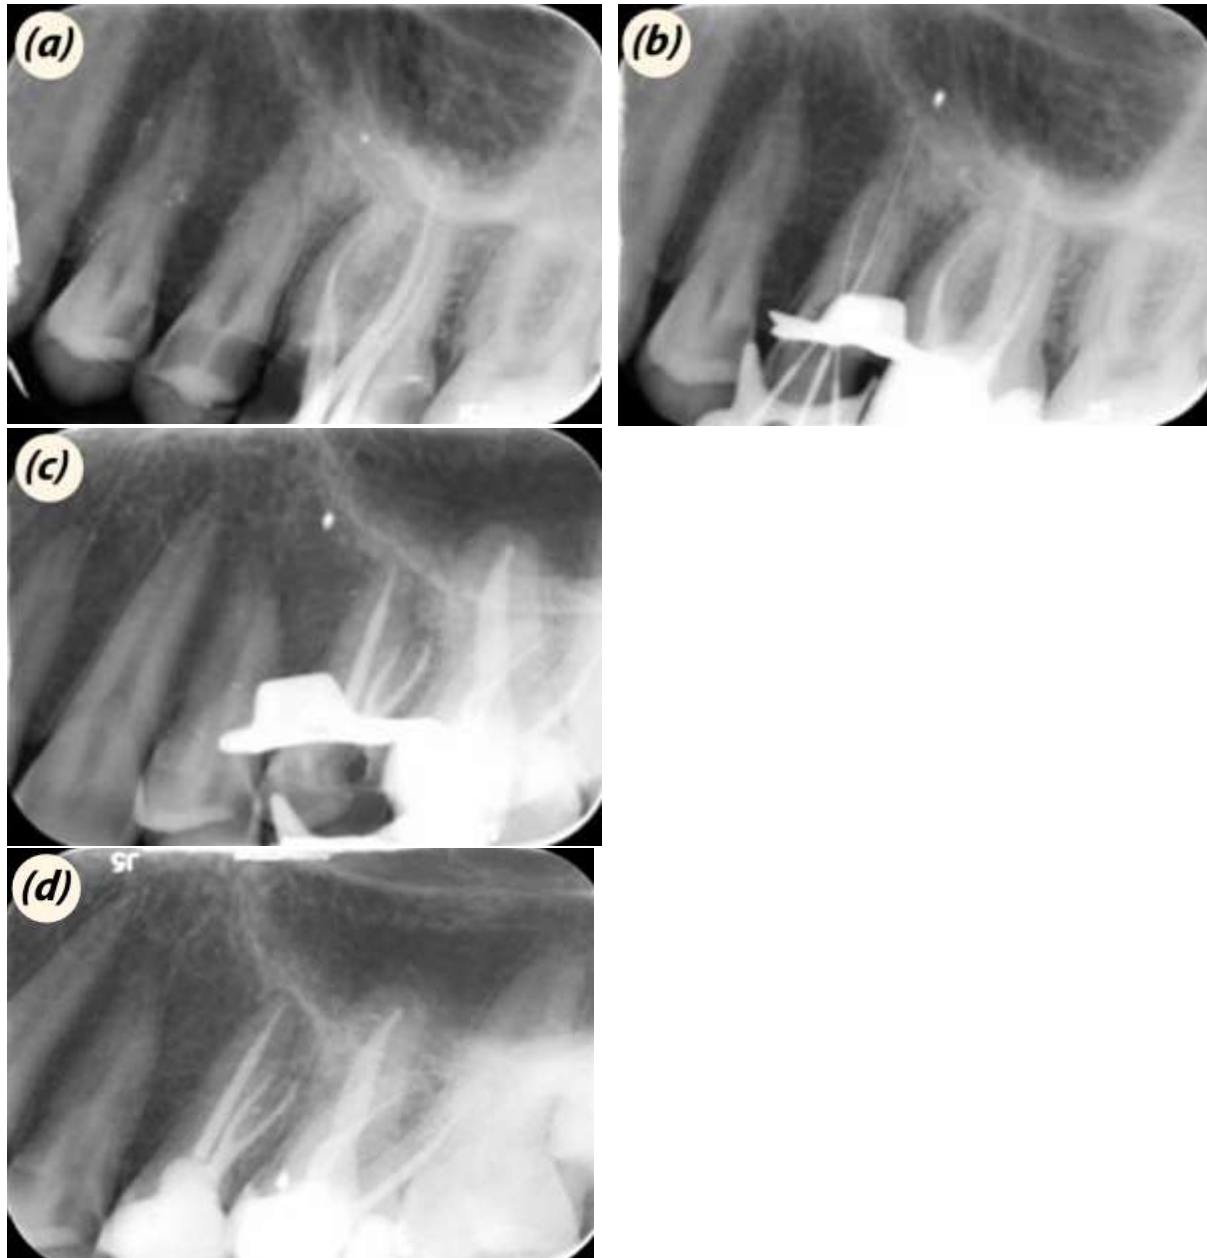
Preoperative radiography (a). Length-determination radiography demonstrating three instrumented root canals (b). Radiographic control following definite obturation three root canals (c). One year follow-up radiographic control (d).
